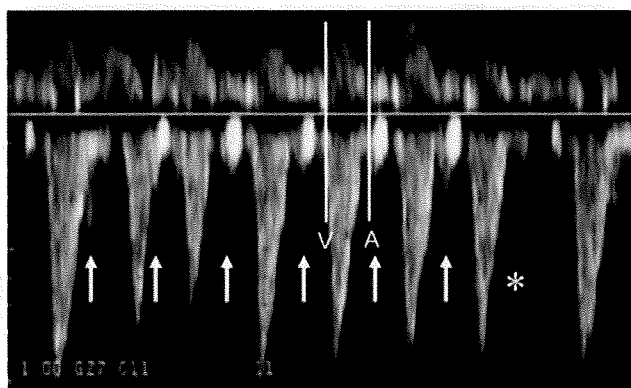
Simultaneous Doppler trace of the ascending aorta and the superior vena cava in a fetus with 1:1 atrioventricular conducted tachycardia with long ventriculo-atrial interval. Tachycardic atrial contraction (A, arrows) disappears after the seventh ventricular contraction (asterisk), and the tachycardia is stopped.
